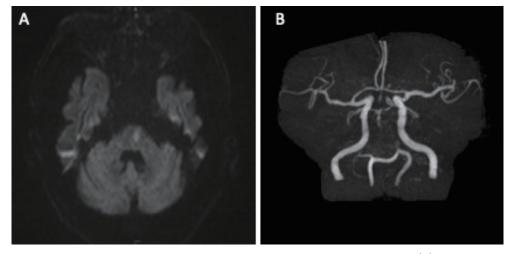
(A) Diffusion-weighted magnetic resonance imaging revealed left pontine infarction. (B) Magnetic resonance angiography (MRA) showed a suspected occlusion of the basilar artery (BA).
